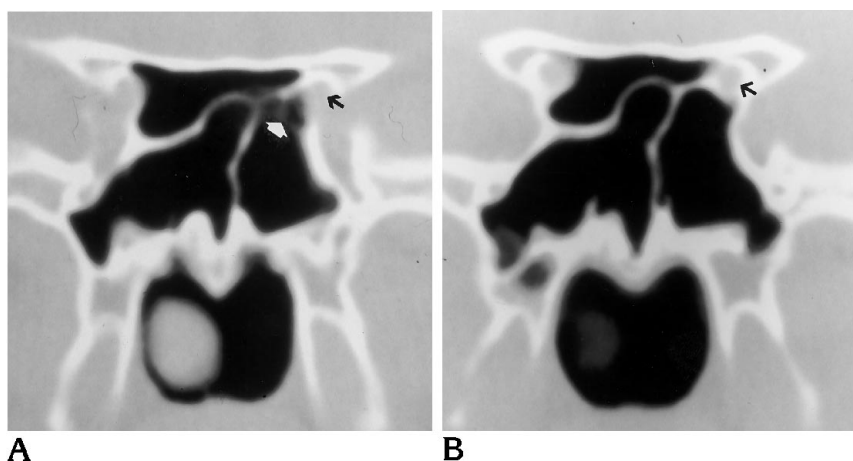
Type 4 optic nerve. Coronal CT scans from anterior (A) to posterior (B) show the optic nerve (black arrows) to be in contact with the posterior ethmoidal sinus at its junction (white arrow) with the sphenoidal sinus.
